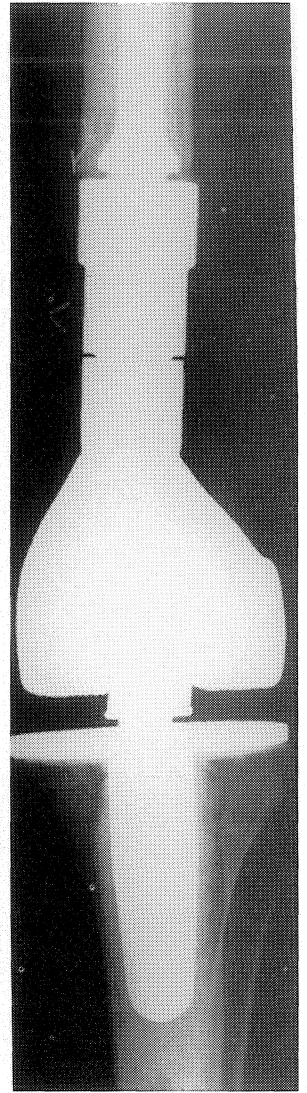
AP radiograph at seventeen months post-resection and reconstruction. Note hypertrophy of fibula.
